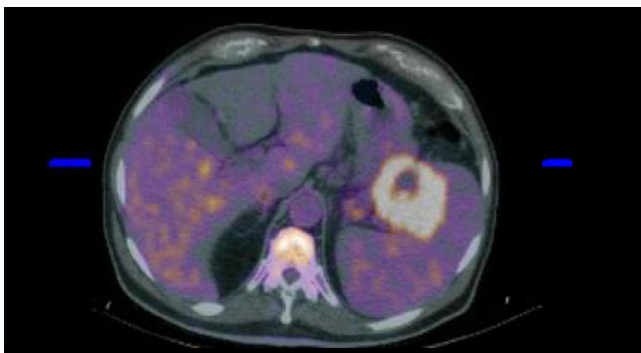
Axial fused Fluorine-18 fluorodeoxyglucose positron emission tomography computed tomography of the abdomen show intense peripheral hypermetabolic activity associated with the pancreatic mass, which is inseparable from the spleen and the proximal greater curvature of the stomach. The mass demonstrates central photopenia likely consistent with tumor necrosis.
